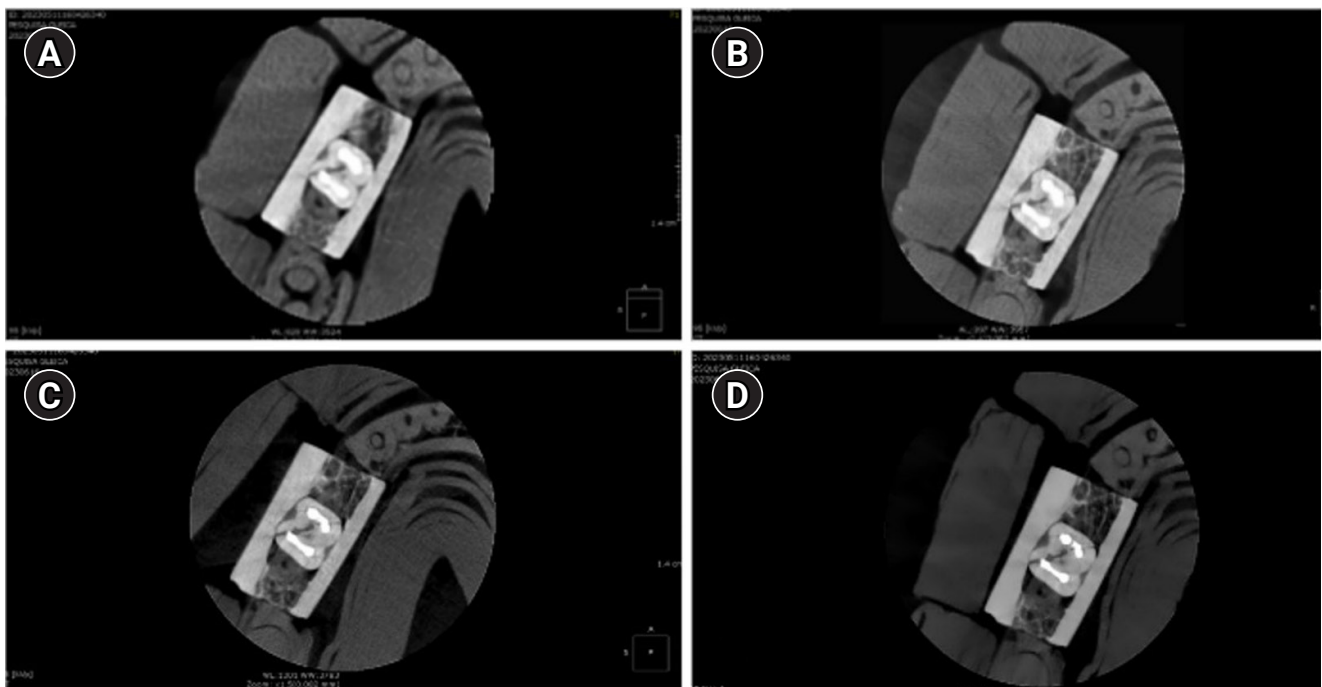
Axial cone-beam computed tomography slices of a sample tooth without post acquired on the four protocols. (A) Low dose resolution, (B) standard resolution, (C) high resolution, and (D) endo resolution.
